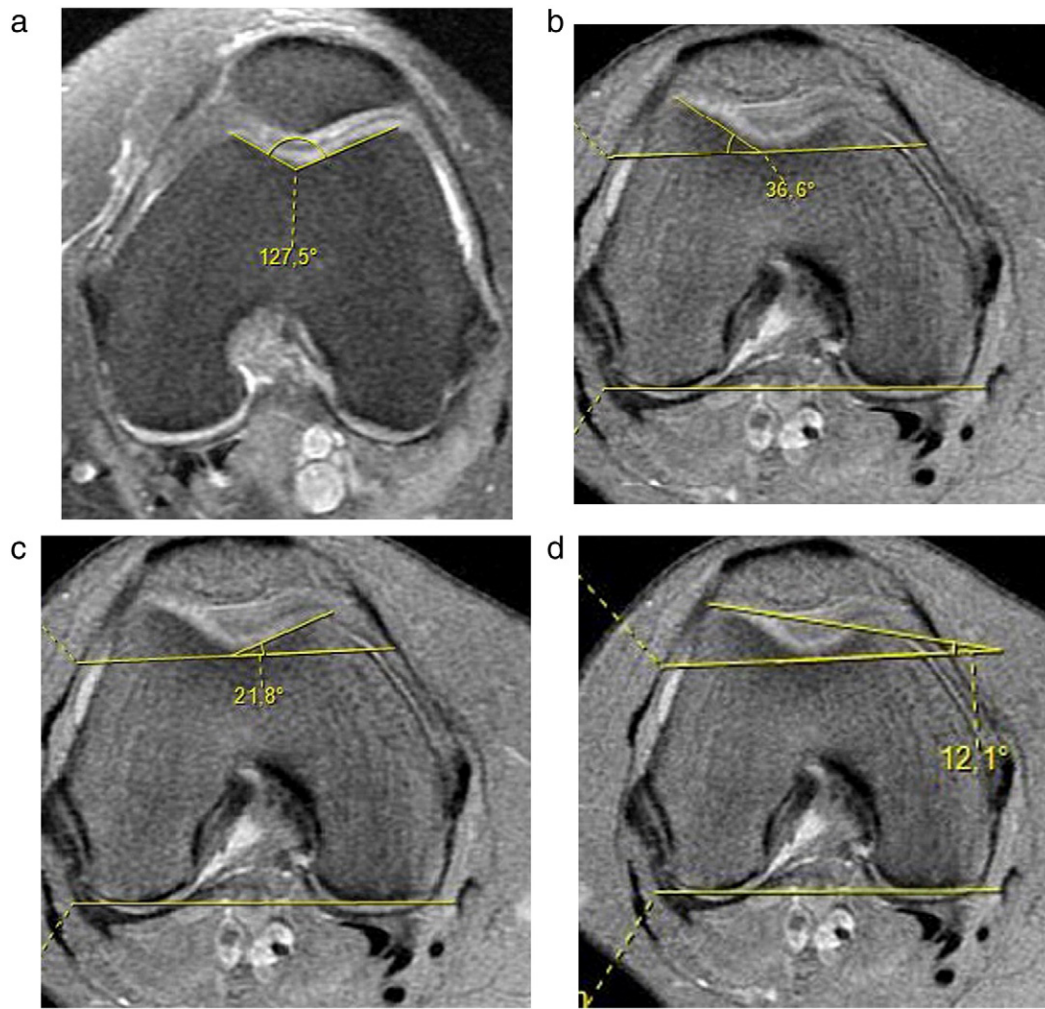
Measurement of SA (a), LTI (b), MTI (c) and TA (d) in a patient on MRI.
